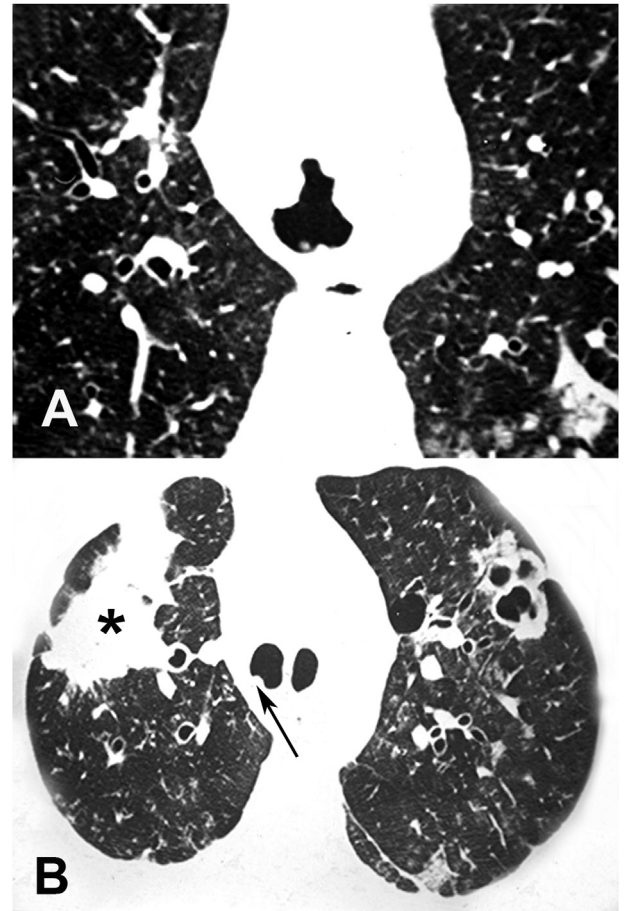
An 18-year-old man with RRP. a Axial CT image obtained with lung window settings at the level of the carina shows airway narrowing caused by nodular vegetant lesions. b Axial CT image obtained with lung window settings at the level of the upper lung regions shows an ill-defined solid mass with irregular margins in the right upper lobe (asterisk), corresponding to squamous cell carcinoma. Note also cavitated confluent lesions in the left upper lobe, and a small papilloma in the right main bronchus (arrow).
